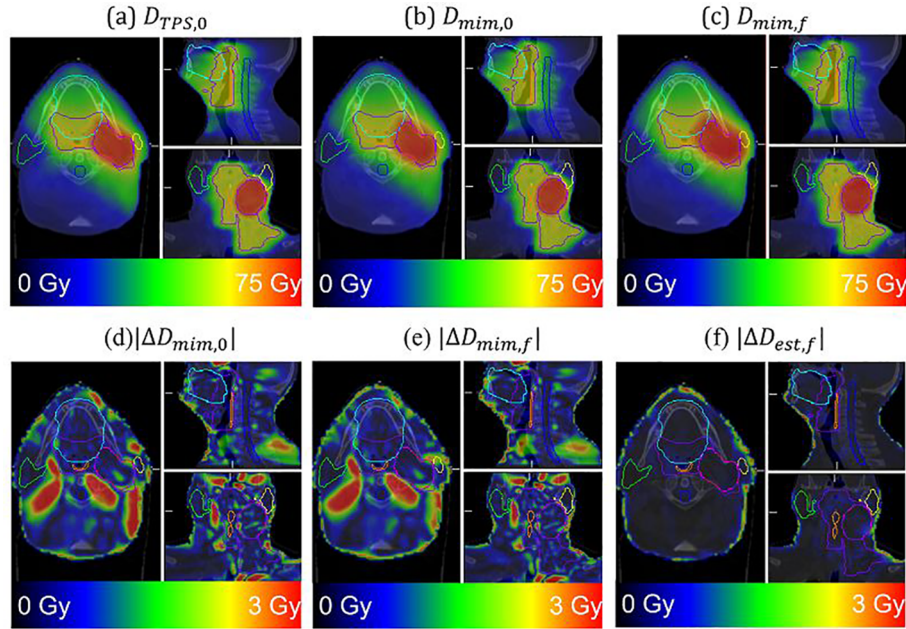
Distributions of (a) planned dose, $D_{TPS,0}$, (b) mimic dose, $D_{mim,0}$, (c) mimic dose during treatment, $D_{mim,f}$, (d) absolute mimic dose error in the planning CT, $|\Delta D_{mim,0}|$, (e) during treatment without correction, $|\Delta D_{mim,f}|$ and f) during treatment with correction, $|\Delta D_{est,f}|$ ($D_{est,f} = D_{mim,f} - \Delta D_{mim,0}$).
